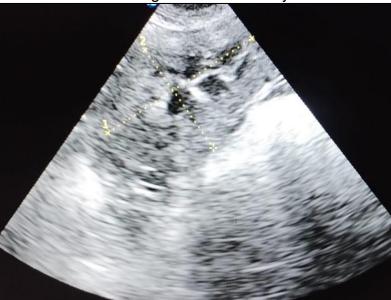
Ultrasound image of the left kidney at reassessment.
